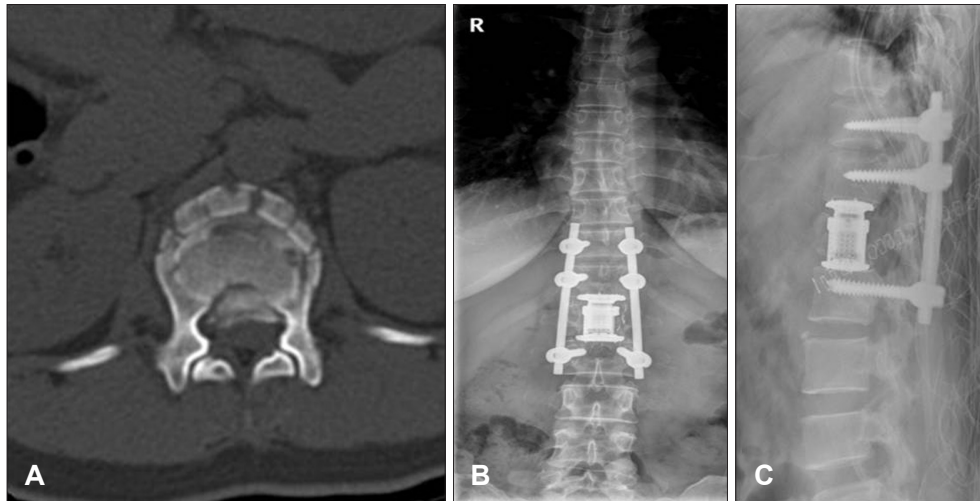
A case of thoracolumbar vertebral fracture managed by 360-degree fusion. A: Axial computed tomography scan image of a fractured spine. Bilateral pedicles and facet joints were resected and a cage was inserted. B and C: Plain radiograph showing cage insertion and transpedicular screw fixation.
